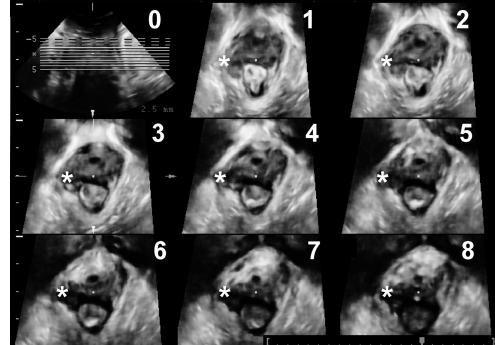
Assessment of the puborectalis muscle by tomographic or multislice ultrasound. Image 0 represents a reference image in the coronal plane. Images 1–8 show slices parallel to the plane of minimal hiatal dimensions. Slices 1 and 2 are 5 and 2.5mm below this plane, slice 3 represents the plane of minimal dimensions and slices 4–8 are 2.5–12.5mm above this plane, likely encompassing the entire insertion of the puborectalis. Reproduced with permission.²⁰
